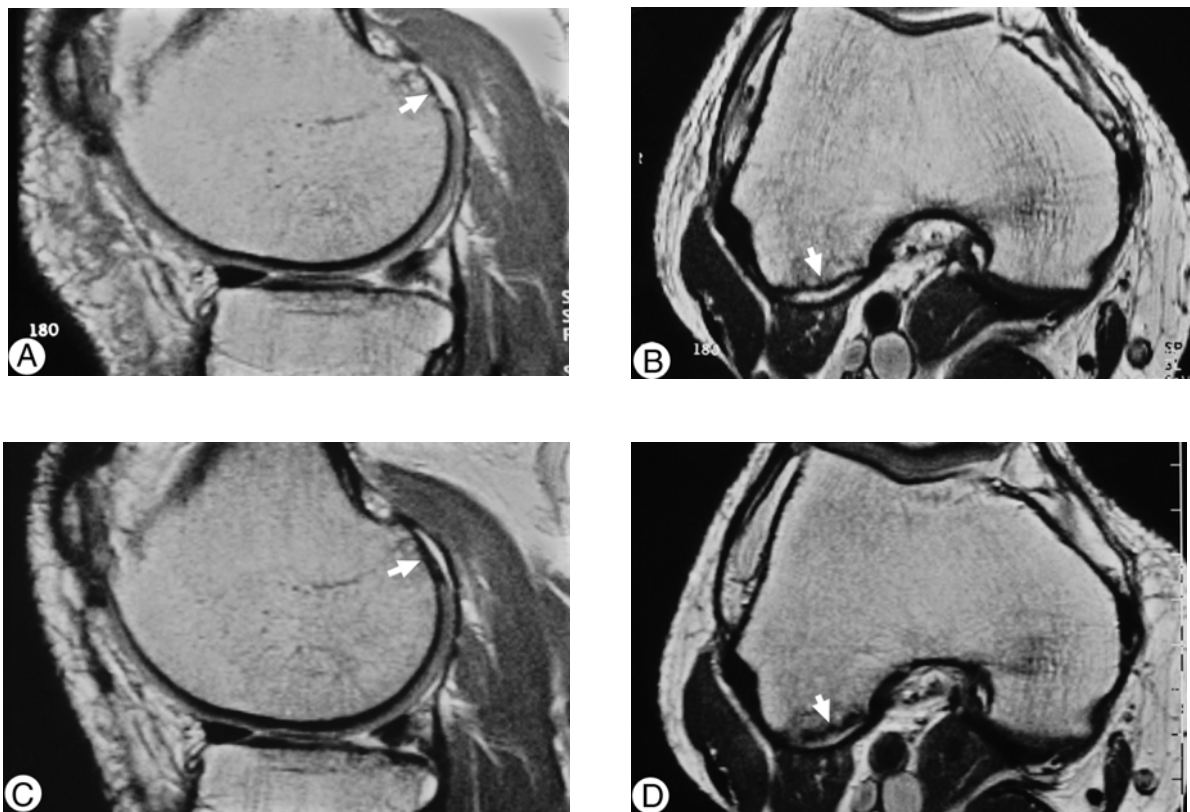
(A) Sagittal and (B) axial Pd-weighted turbo-spin echo MR images showing a cartilage defect of grade 2 at the dorsal aspect of the lateral femoral condyle (arrow) in a 44-year-old man at the baseline examination. The corresponding MR images after 24 months, (C) and (D), show that the defect is partially filled in.
